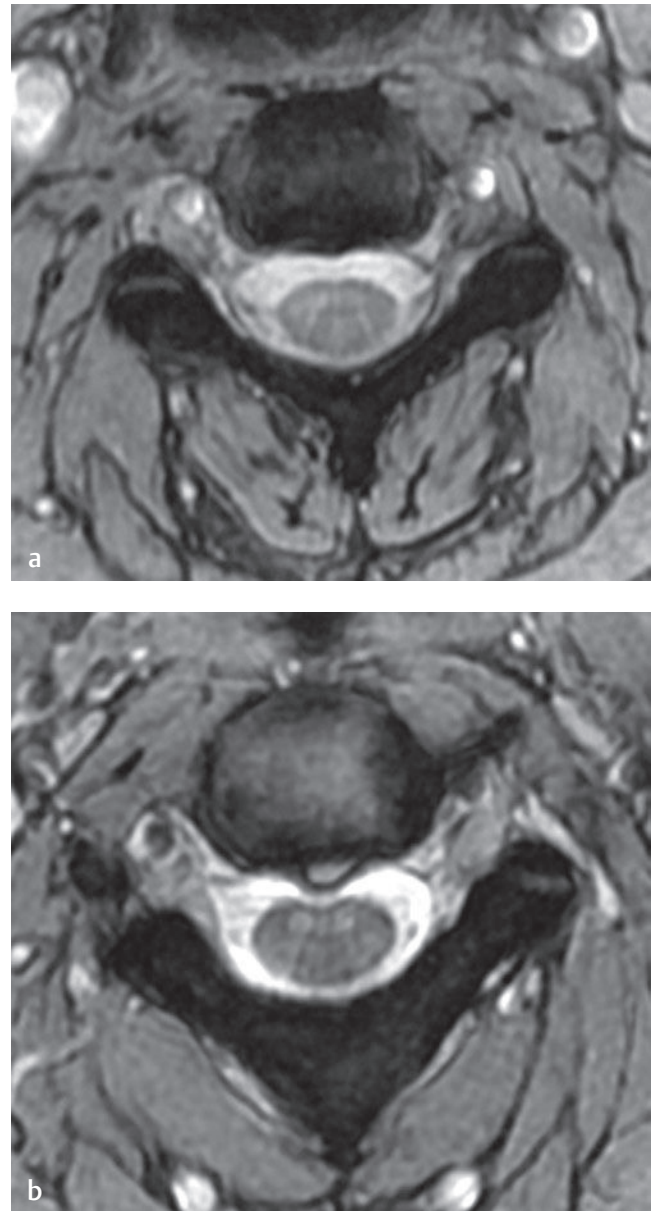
Morphology of disc herniations. (a) A normal cervical disc on an axial T2-weighted image conforms to the morphology of the adjacent vertebral bodies. (b) In a different patient, an axial view shows a central disc protrusion extending posterior to the margins of the adjacent vertebral bodies and indenting the anterior aspect of the thecal sac. Note the brighter T2-weighted signal, which is secondary to hemorrhage, in the acute disc herniation.
